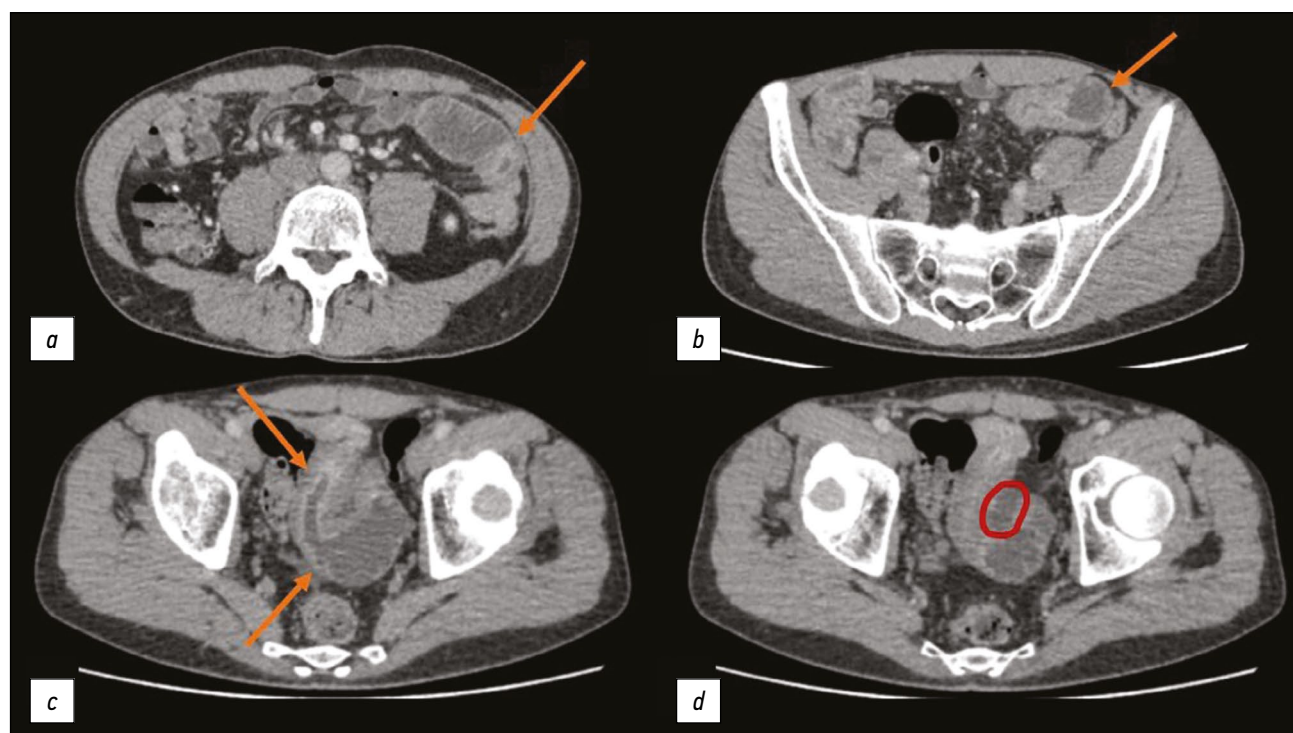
Abdominal multislice computed tomography with intravenous contrast, axial plane: *a*) substantial narrowing of the intestinal lumen and thickening of the wall with active contrast agent accumulation (arrow); *b*) dilated loop of the small intestine with an unevenly thickened wall (arrow); *c*) dilation and narrowing of the intestinal lumen is visible; additionally, of interest is the intestinal mucosa, which actively accumulates the contrast agent (arrows); *d*) the area of fluid accumulation between the loops in the small pelvis is marked red.
